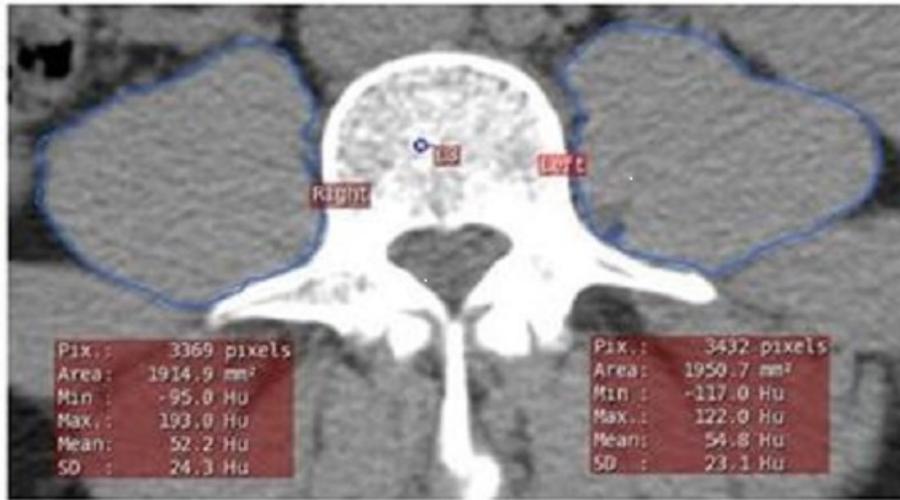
CT image analysis. Tracings of right and left psoas muscles at the third lumbar vertebrae level (L3)
